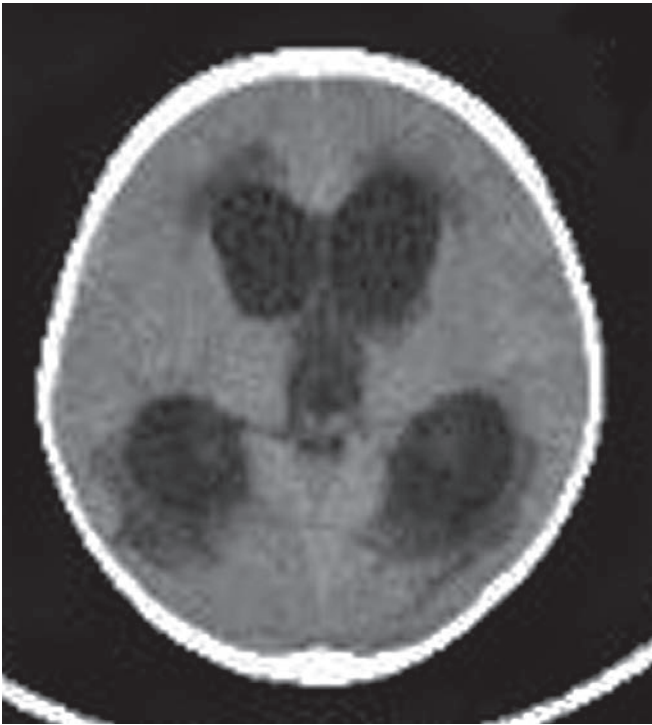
Tuberculous meningitis. CT brain showing moderate communicating hydrocephalus with periventricular hypodensities—suggestive of CSF seepage. Enhancing basal exudates noted
